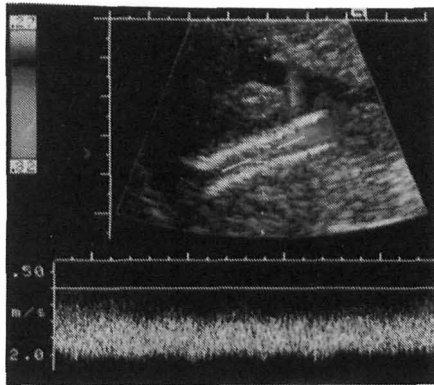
Color Doppler sonogram obtained in a 53-year-old man shows brisk flow along the entire length of the stent up to the inferior vena cava (\*). Aliasing (coded red-yellow) (arrow) is prominent in the hepatic vein end of the stent. Antegrade, hepatopetal flow is preserved through the right branch of the portal vein (arrowheads) peripheral to the stent entry point.
